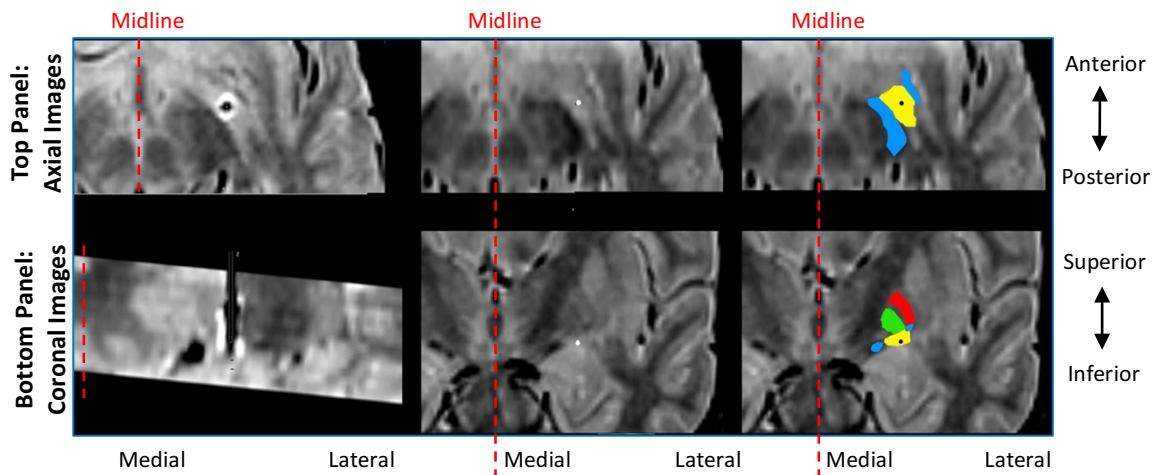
Determining DBS lead contact location from stereotactic, proton density MR images (Siemens Espree, 1.5T): First column (above: axial image; below: coronal reconstruction along lead trajectory, magnified): Stereotactic MR images obtained after lead implantation were imported into a dedicated software platform (FrameLink, Medtronic). Images were reconstructed along the axis of the lead and a template placed on the lead artefact to determine the stereotactic coordinates of each contact. Second column (above: axial; below: coronal): The stereotactic coordinates for each contact were then transposed onto preoperative stereotactic images, allowing an accurate assessment of lead location (white dot). Third column (above: axial; below: coronal): The heavily myelinated optic tract and anterior commissure (lateral extension), hypointense on proton density MR images, are coloured light blue. The intervening hyperintense nucleus basalis of Meynert (NBM) lies between these two structures and is coloured yellow. In the coronal image the NBM is seen to lie superior to the temporal lobe (amygdala / supra amygdala complex) and inferior to the internal (green) and external (red) segments of the globus pallidus. The active contact (black dot) is seen to lie within the NBM.
